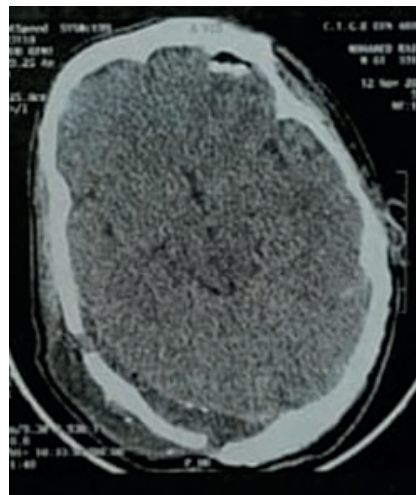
Axial section of a brain computed tomography scan immediately after surgical evacuation of the supratentorial infratentorial epidural hematoma.
